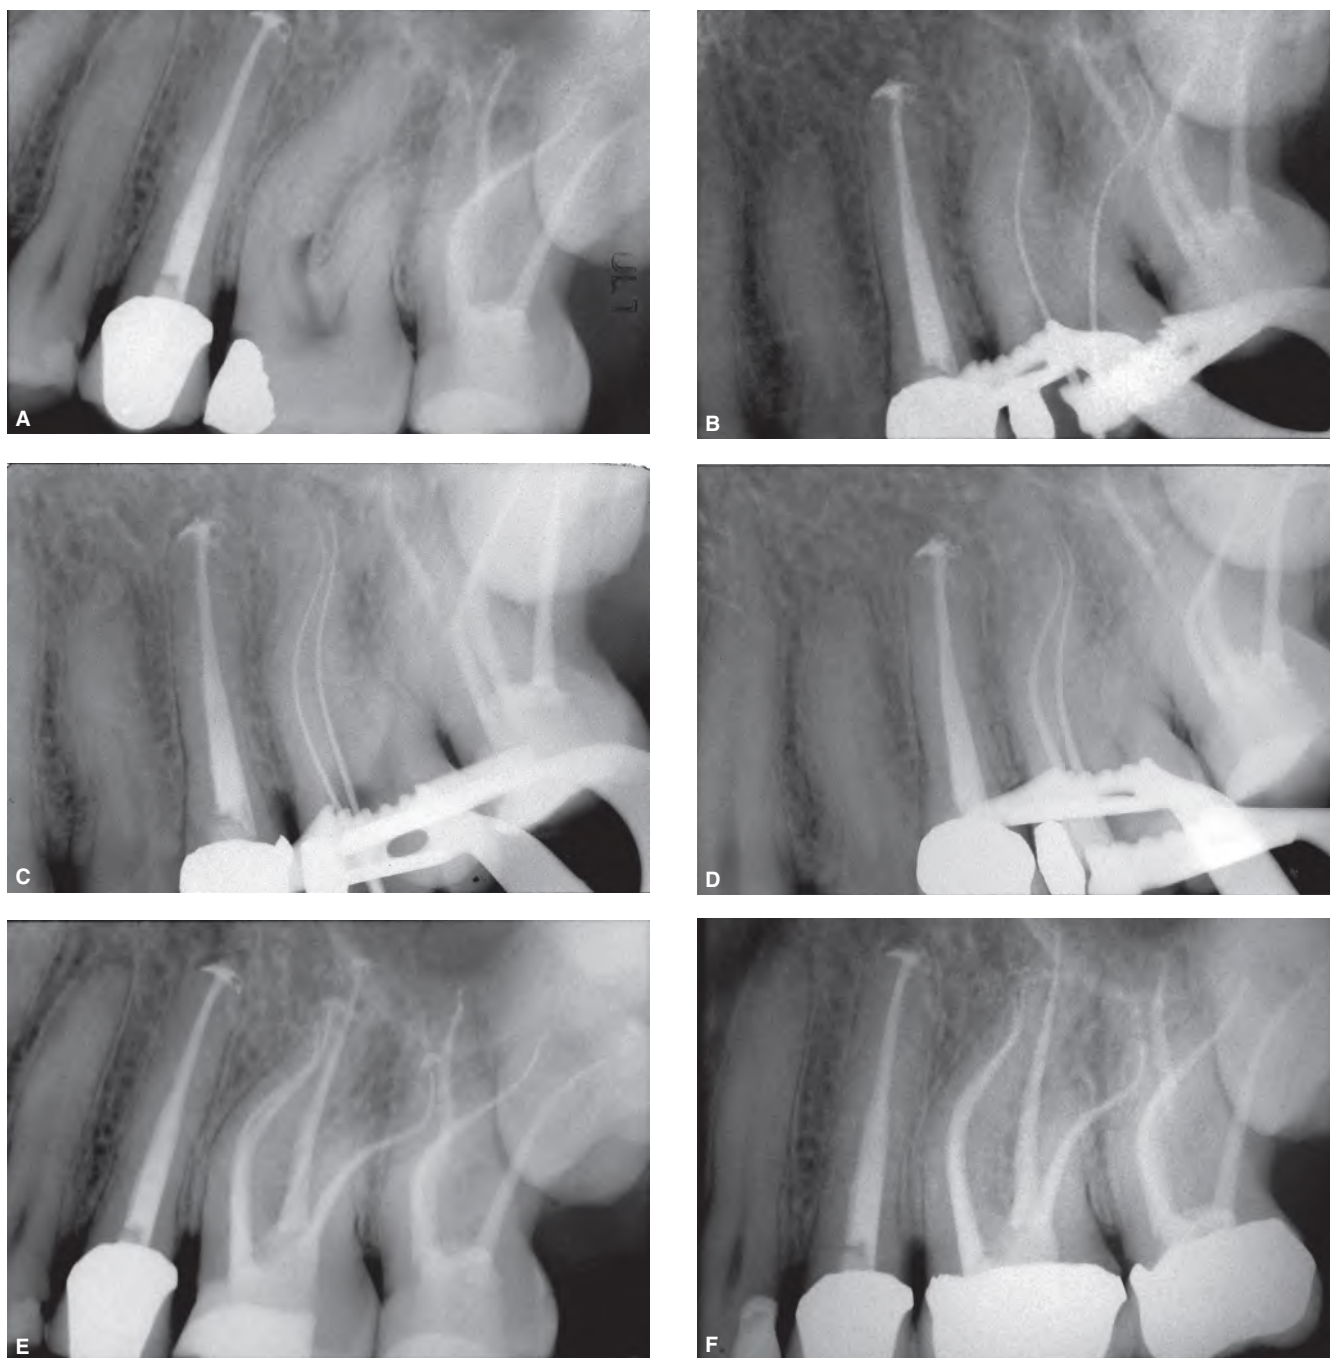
A. Preoperative radiograph of the maxillary left first molar. The second molar has already been obturated with Thermafil. B. Working length of the MB-1 and DB canals. C. Working length of the MB-1 and MB-2 canal. D. Plastic carriers in the MB-1 and MB-2. E. Postoperative radiograph. F. Two-year recall radiograph showing that the therapy has been successful. (Courtesy of Dr. Giuseppe Cantatore, Rome, Italy.)
